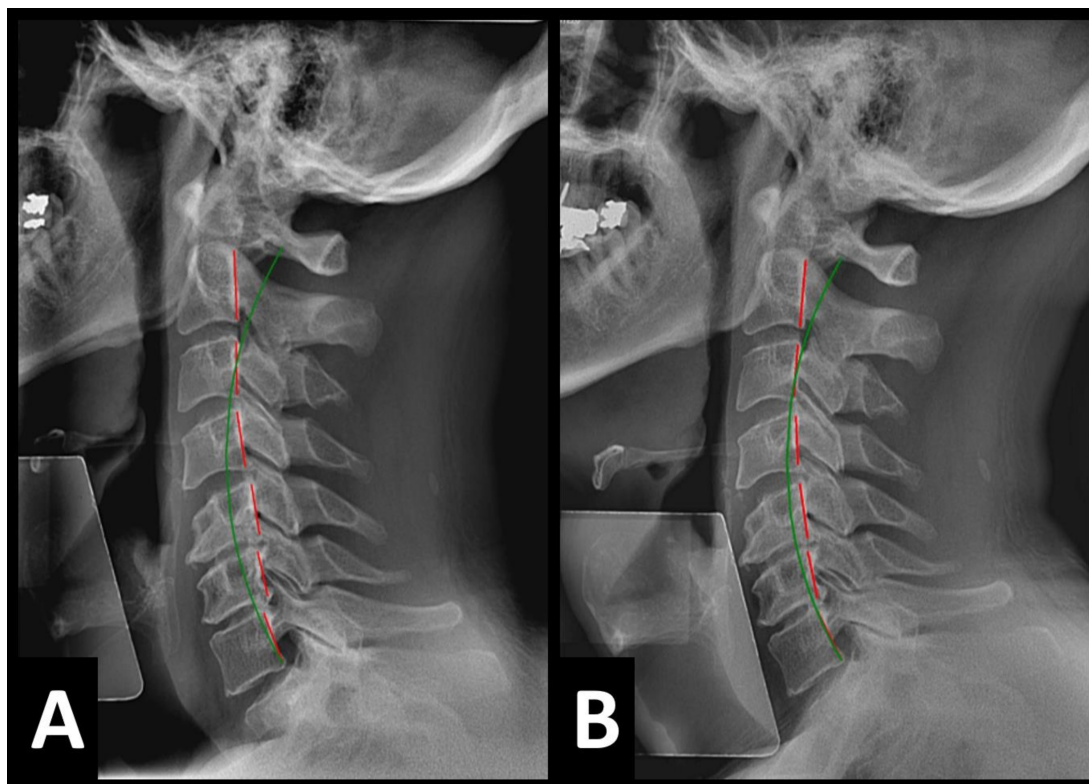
Initial and Final Neutral Lateral Cervical Radiographs Example 2
